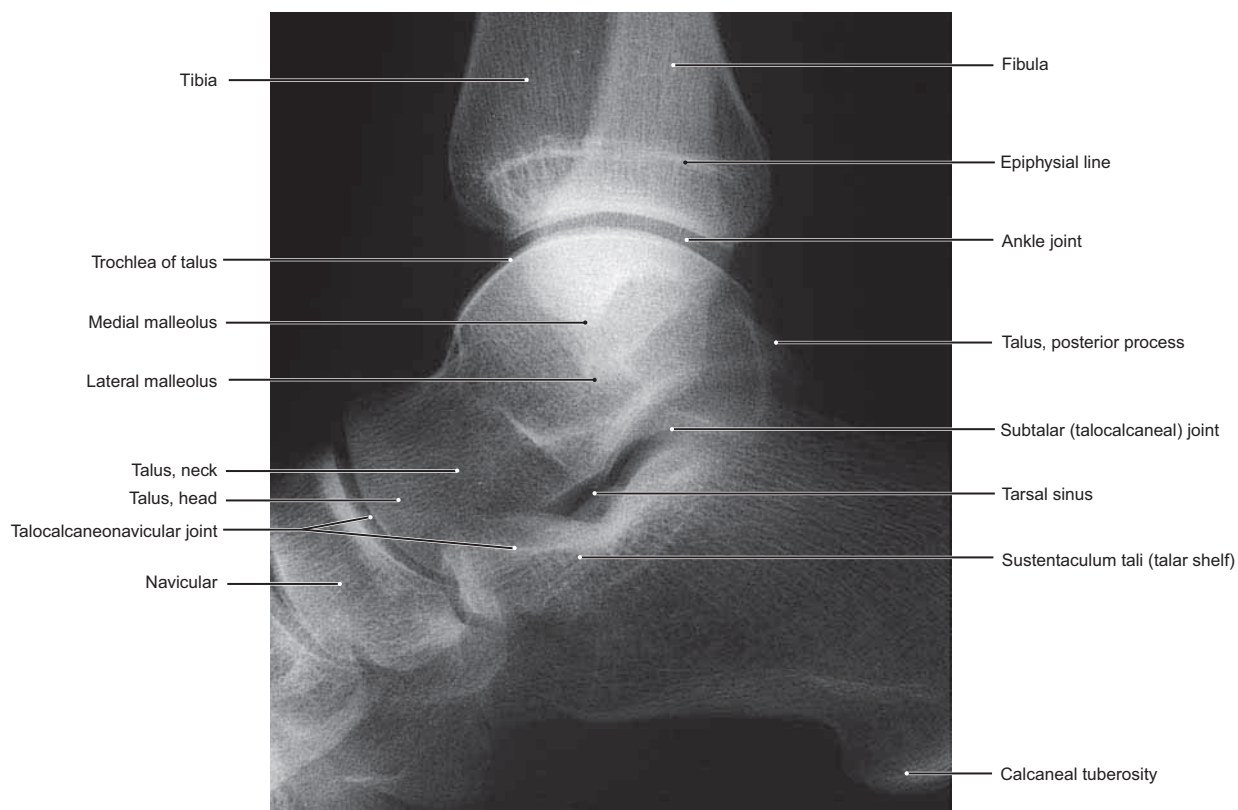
Lateral Radiograph of the Subtalar and Talocalcaneonavicular Joints
